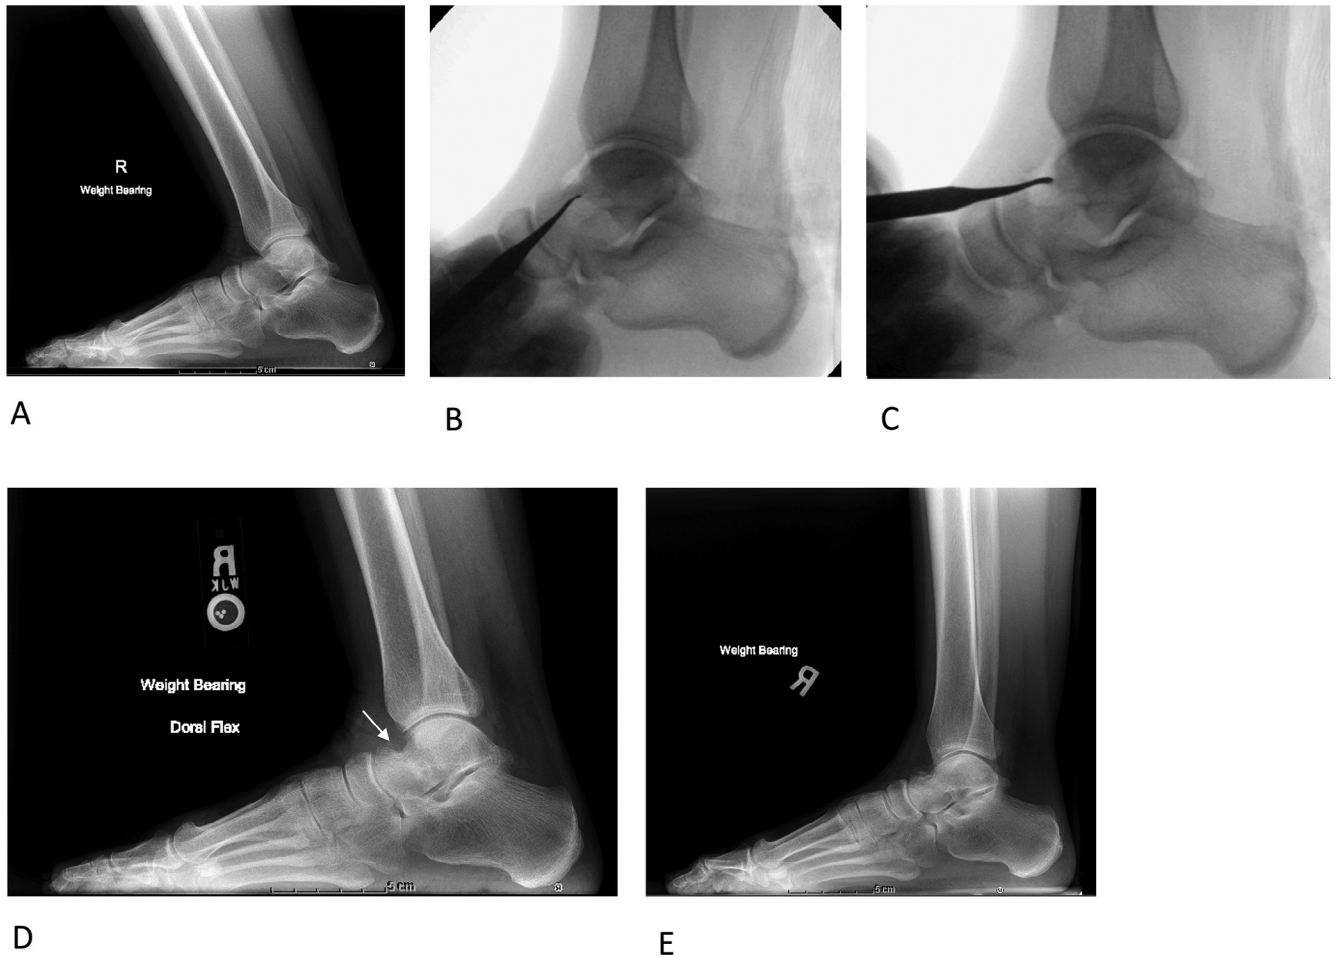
A 55-year-old woman with cheilectomy complicated by a talar neck insufficiency fracture. The preoperative lateral ankle radiograph in dorsiflexion (A) demonstrates tibiotalar osteoarthritis and osteophytosis of the talar neck. The patient subsequently underwent cheilectomy of the talar neck with the intraoperative fluoroscopic images (B and C) demonstrating the resection of the osteophyte at the dorsal aspect of the talar neck. Six weeks after the ankle cheilectomy, a lateral foot radiograph in dorsiflexion (D) demonstrates a sclerotic line at the talar neck (arrow), concerning for a fracture. The patient was subsequently placed in a controlled ankle movement boot. Lateral view of the foot radiograph 10 months later (E) demonstrates a decreased conspicuity of the fracture line, consistent with interval healing.
